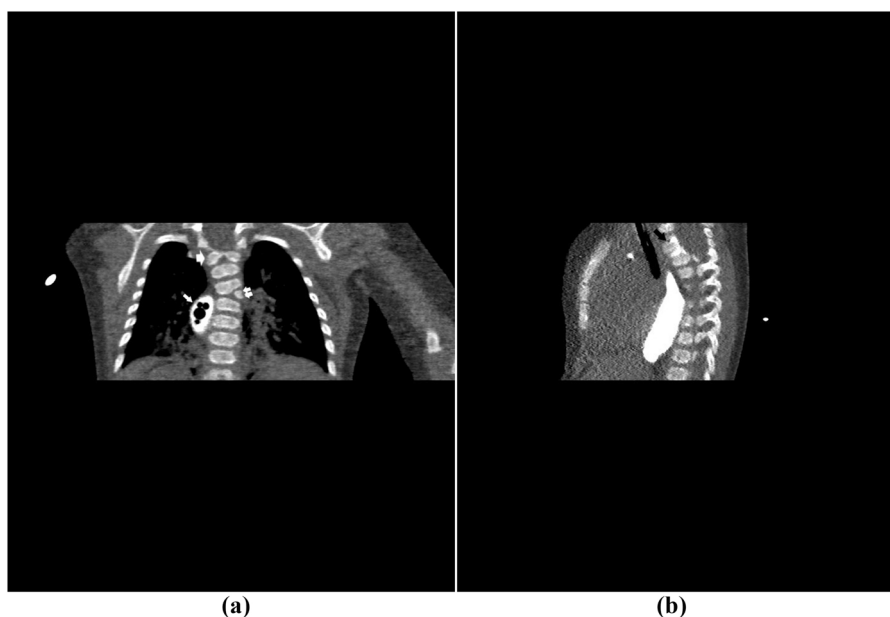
3a: Coronal CT scan during the guided aspiration. The right posterior mediastinal cyst (arrow) has been emptied and filled with contrast. Notice the thoracic hemivertebra (double arrows) and the upper thoracic vertebral body cleft (wide arrow). 3b: Sagittal CT scan. The contrast fills the posterior mediastinal cyst, and spreads through the communication channel (black arrow) through vertebral bodies, till it reaches the intraspinal compartment.
